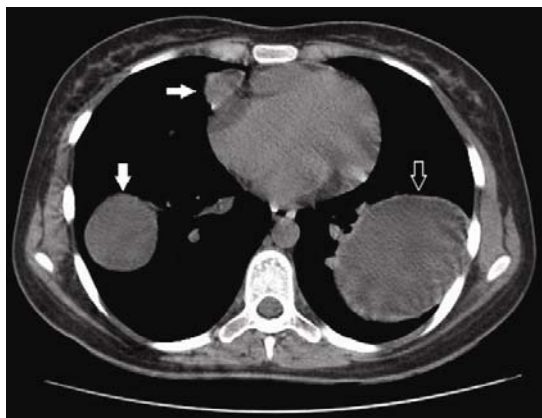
Chest computed tomography scan demonstrated one large cystic mass in the left lung (arrow) and two in the right lung (white arrow).
